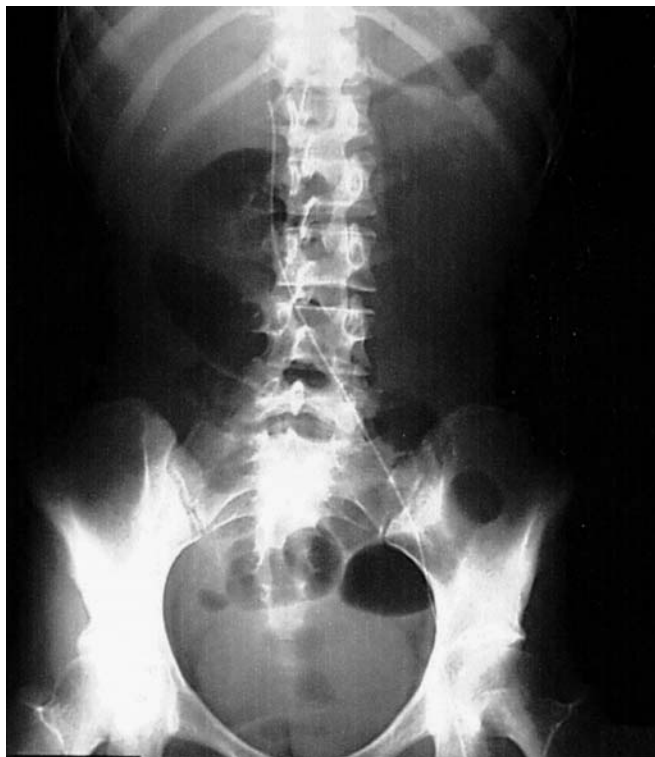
Abdominal X-ray (supine position) on admission to this hospital showing dilatation of the small intestine
